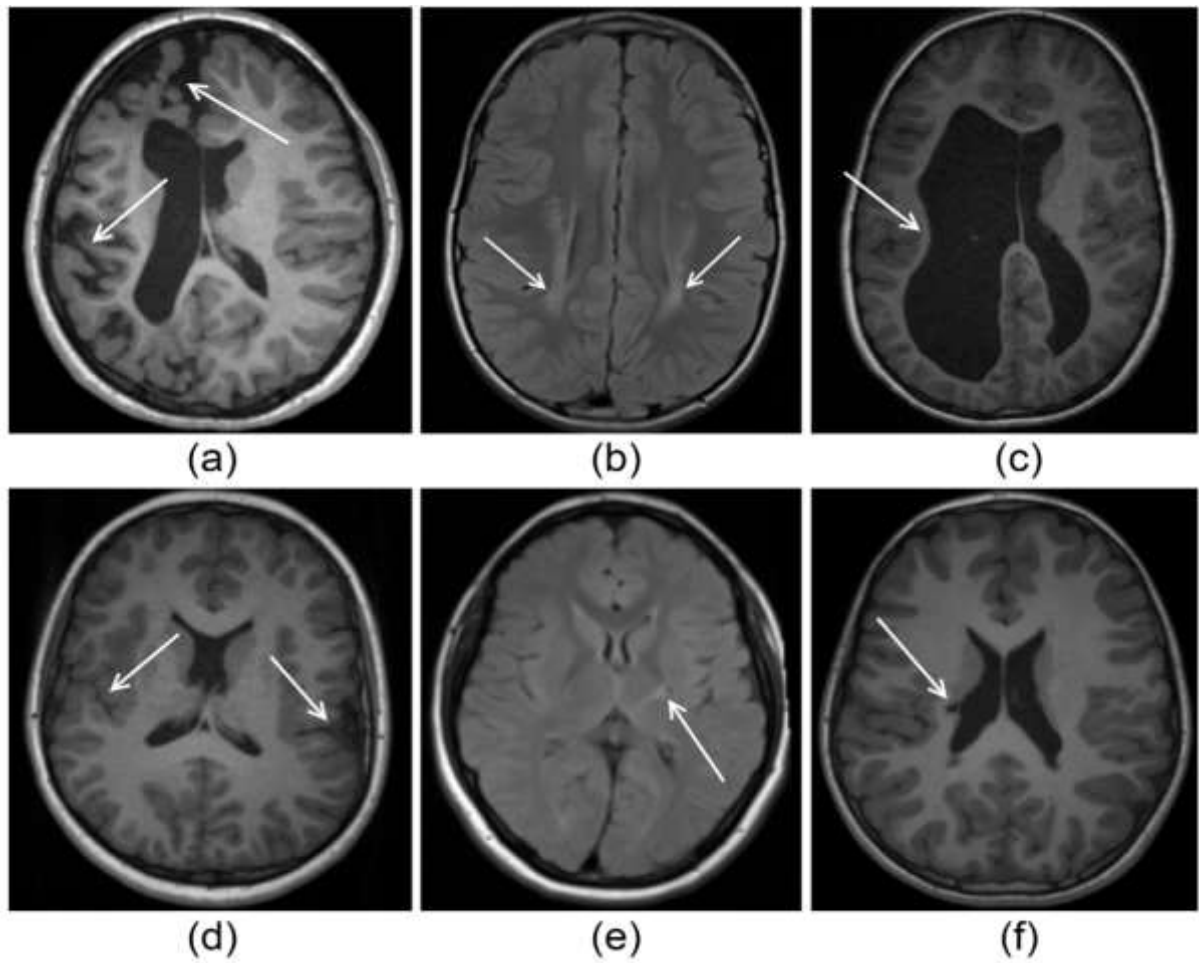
Structural magnetic resonance images of different sites and types of brain injury related to cerebral palsy from (Pagnozzi et al., 2017)
